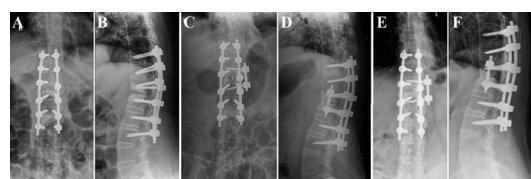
(A, B) Antero-posterior and lateral postoperative radiographs following posterior spinal stabilisation and instrumented fusion of D9–L2 vertebra, later followed by (C and D) minimally invasive anterior discectomy, anterolateral interbody fusion of D11–D12 with cage and bone grafting. (E and F) Follow-up radiographs 1 year following surgery, showing no recurrence of Andersson lesion.
